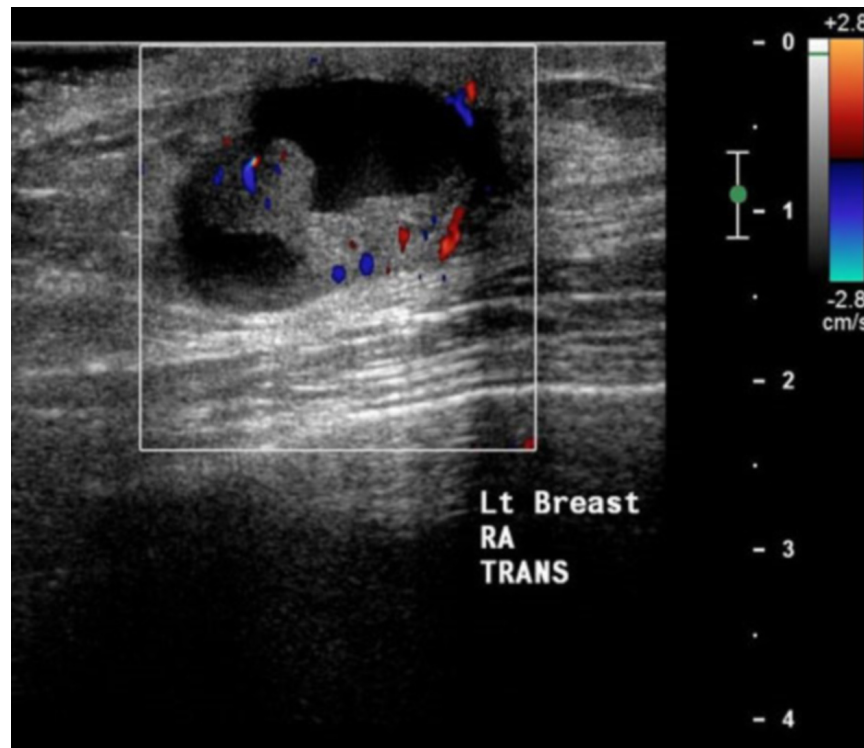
70-year-old man with intracystic papillary carcinoma. At presentation, Doppler sonogram of left breast mass demonstrated blood flow in the nodular component.
